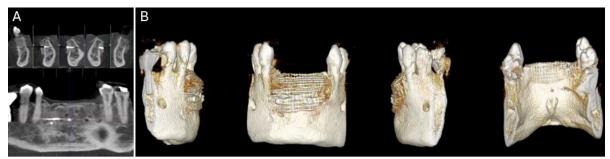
Postoperative assessment of graft placement. (A) Postoperative radiographic control showing the correct placement of the regenerative material. (B) Postoperative 3D rendering with OsiriX confirming accurate three-dimensional positioning of the graft.
